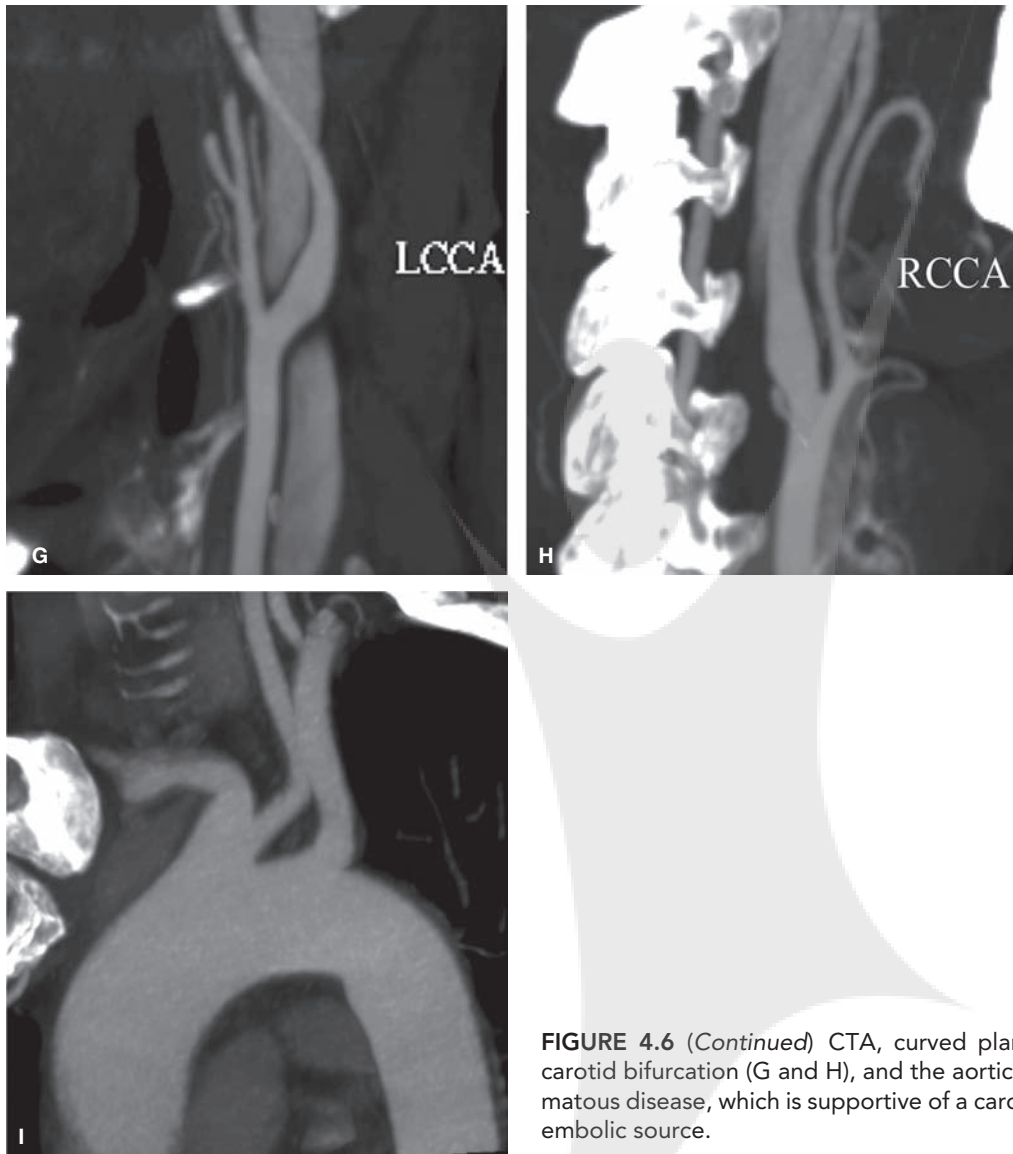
Embolic left MCA occlusion. Sixty-two-year-old male with known left ventricular thrombus following myocardial infarction awoke with right hemiparesis and aphasia, last seen normal 13 hours prior to imaging. Noncontrast CT (A and B) reveals a hyperdense clot in the left MCA stem (arrowhead), with subtle sulcal effacement and loss of gray–white matter differentiation throughout a large portion of the left MCA territory (delineated by arrows). Thin-section CTA source images (C) show absent enhancement within the occluded left MCA stem (arrowhead) as well as the distal left MCA branches and arterial collaterals (delineated by arrows). Thick-section (5 mm) CTA source images (D and E) more clearly demonstrate a large area of hypoperfused brain tissue in the left MCA territory (delineated by arrows). Coronal MIP CTA image (F) clearly depicts the absent enhancement of the left MCA stem caused by embolic occlusion (arrowhead), as well as the absent enhancement in the distal left MCA branches and arterial collaterals. (Continued)
